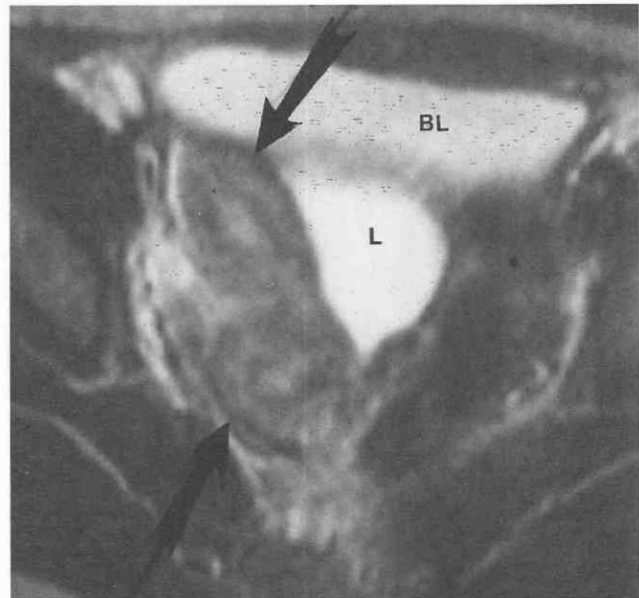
Bicornuate uterus. T2-weighted (2500/90) MR image shows two uterine bodies (arrows) separated by intermediate-signal-intensity myometrium. The fundal contour is concave, and there is a deep cleft between the two uterine horns. The uterine horns are of a similar size and have differentiated zonal anatomy. The high-signal-intensity fluid collection to the left of the duplicated uterus represents a lymphocele (L). BL, bladder.
